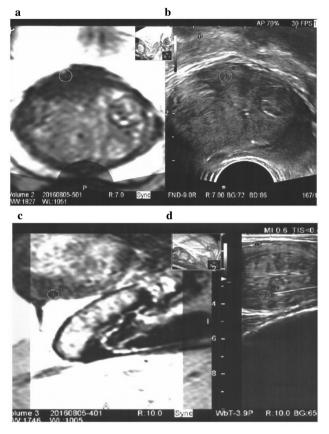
Multiparametric MRI/TRUS fusion image (caliper) of a prostate cancer located in the anterior zone (a: axial T2W - PI-RADS 4; b: axial TRUS). Transperineal mpMRI/TRUS fusion targeted biopsy of the suspicious lesion (c: sagittal mpMRI; d: sagittal TRUS during fusion targeted biopsy).
